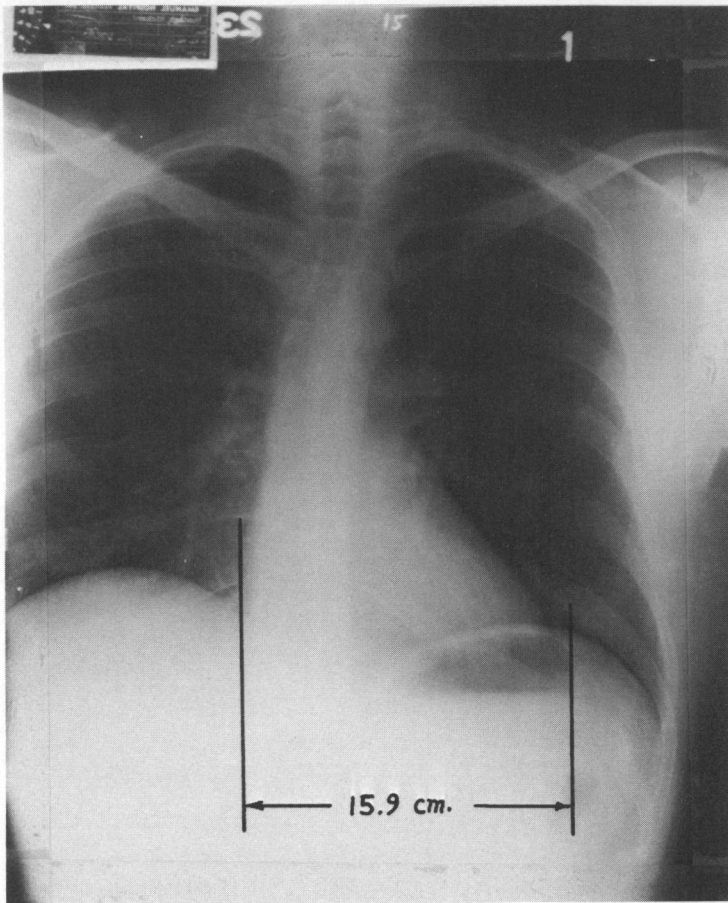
Radiograph of systolic cardiac phase at maximum inspiration
